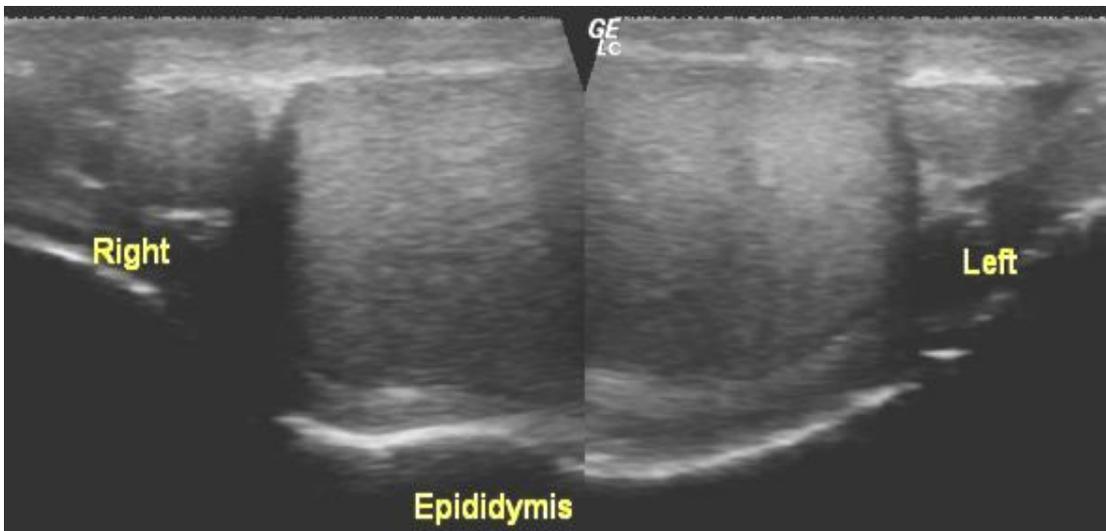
Image of ultrasound scanning of the normal epididymis.
